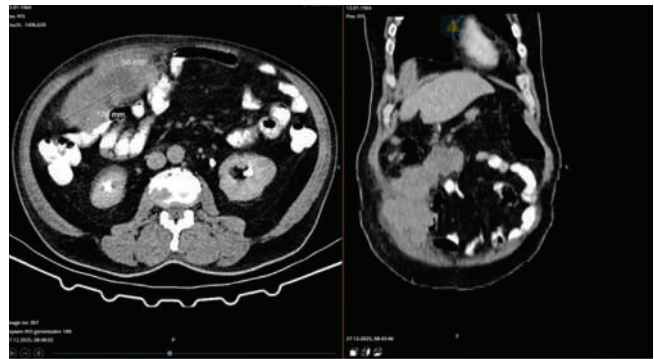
CT image of axial and coronal sections.
